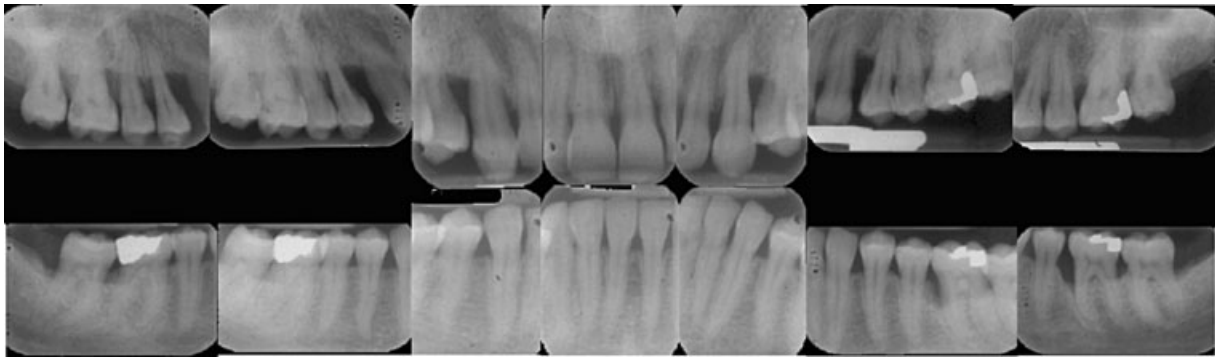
Radiographs of the patient presented in Fig. 31-2.
